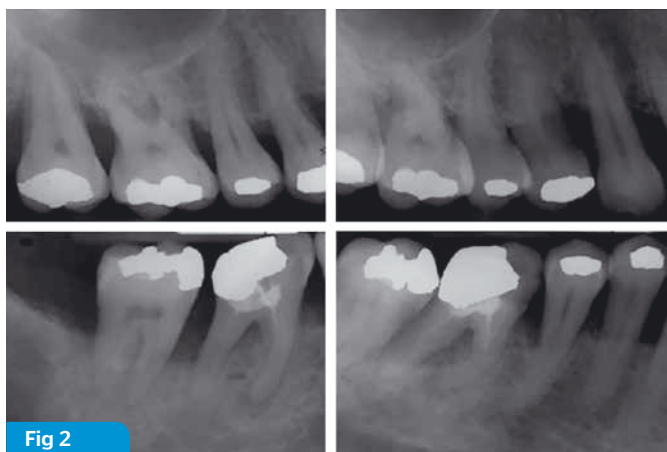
Periapical radiographs at time of initial presentation
